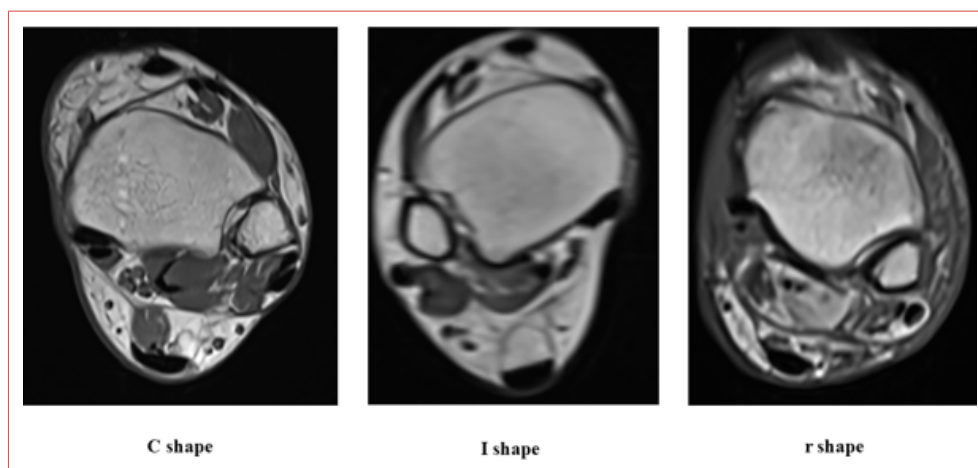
Representative axial magnetic resonance imaging examples of the three fibular notch morphology types: C-type (concave), I-type (shallow and flat), and r-type (rounded, with a smooth transition between the anterior and posterior tibial tubercles).
